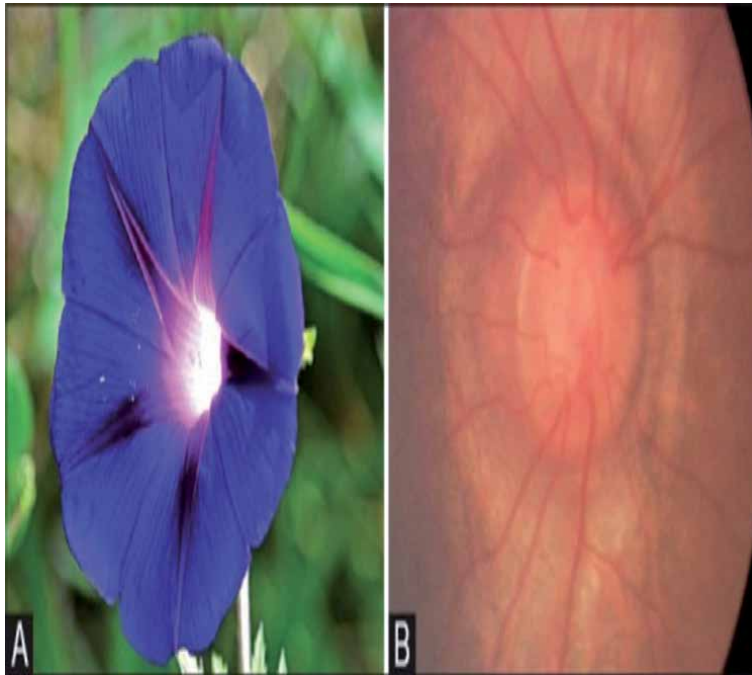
Showing morning glory disc [courtesy:Indian J Radiol imaging. 2018 Apr-Jun] [22]. MRI brain CISS sequence of orbit region may further confirm funnel-shaped excavation of the posterior globe in morning glory syndrome of Moyamoya disease (Figure 3) [22].
